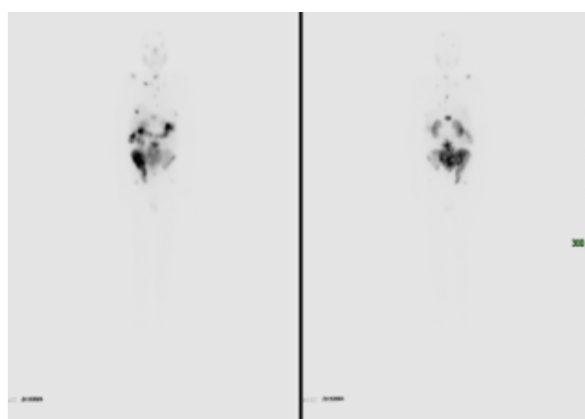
Patient with a history of pT3bN0M1b castration-resistant prostate cancer, with polyostotic bone metastatic involvement and disease in the prostate bed. Two days after administration of 200 mCi of ^{177}Lu -PSMA, a whole body scan was performed in anterior and posterior projections. Physiological distribution of lutetium in liver, spleen and kidneys is observed. In the total body scan, retention of the radiopharmaceutical was observed in multiple bone lesions: right clavicle, thoracic and lumbar vertebral bodies, sacral region, right and left iliac wing, right acetabulum. All the findings show expression of PSMA receptors in the PET/CT ^{68}Ga -PSMA 11
